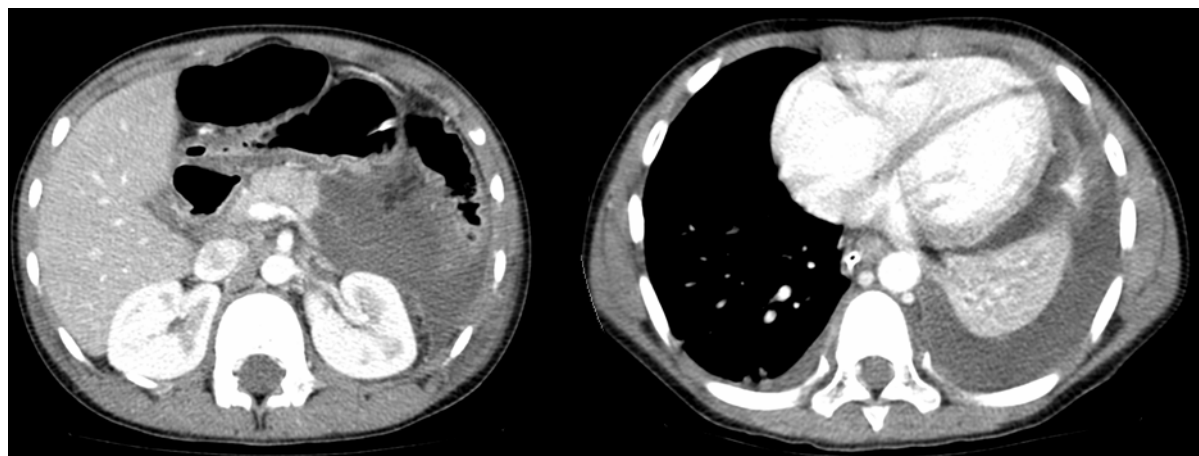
Abdominal and thoracic CT scan showing (A) necrosis involving most of body and tail of the pancreas with a minimal amount of ascites, (B) a left-sided abundant pleural effusion.
